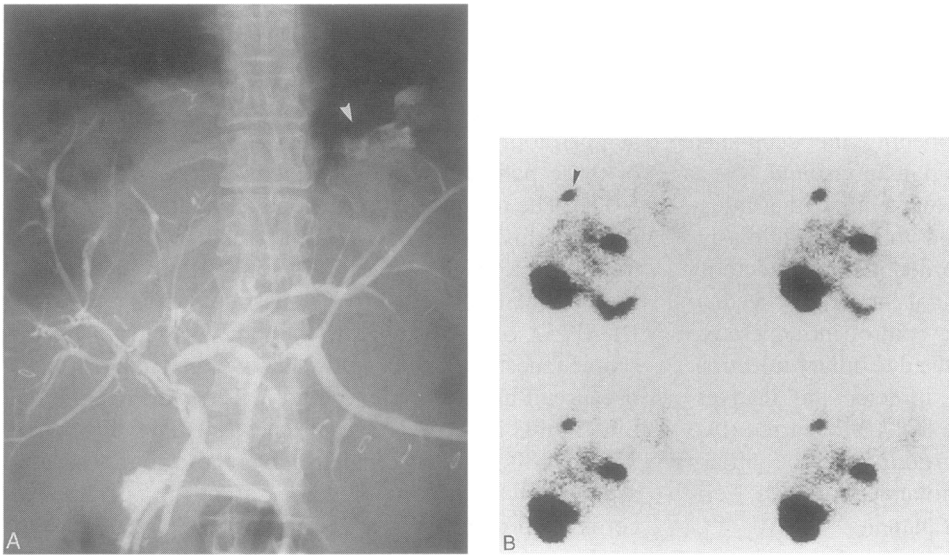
Biliary complications during open fenestration procedure in patients with adult polycystic liver disease. (A) Intraoperative cholangiogram shows contrast extravasation (arrow) within a left liver cyst after open fenestration. (B) Postoperative technetium 99m-iminodiacetic acid biliary scintigraphy shows localized extravasation in one liver cyst after open fenestration in another patient. Spontaneous resolution occurred in this case.
